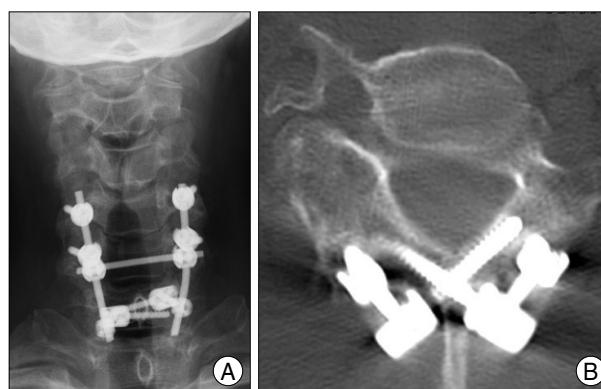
Postoperative image of C7 fixation using bilateral crossing intralaminar screw. A : Postoperative radiograph shows bilateral C5-6 lateral mass screws that are connected to C7 intralaminar screw with rod construct. B : Postoperative computed tomography scan demonstrates bilateral crossing intralaminar screw connected to lateral connector at C7 lamina.
